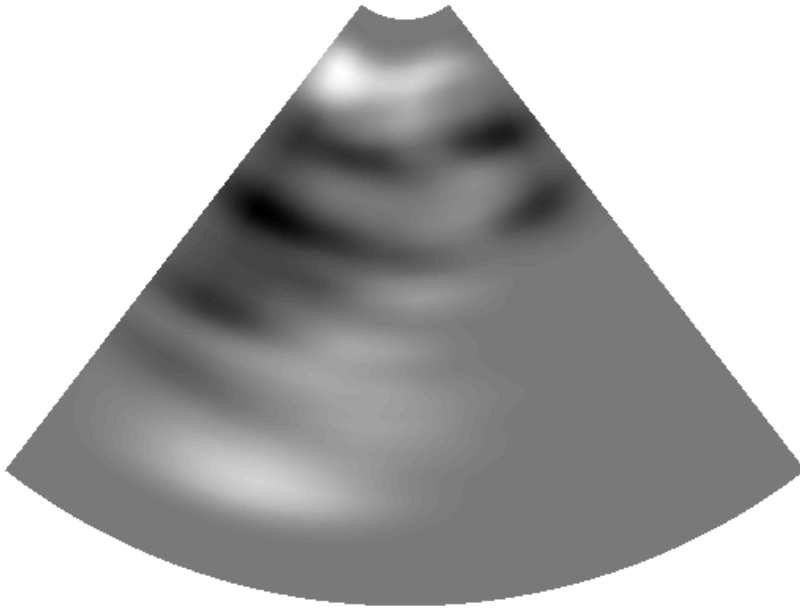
The detected IPB image from the example sonogram (Fig. 4.1). The gray values have been log transformed for paper display purposes, and the difference between darkest black and brightest white area is 5 dB.
